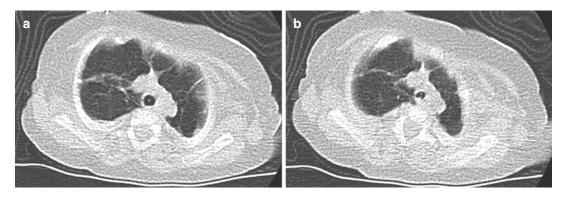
PEEP study. (a) Axial low-dose limited CT in a tracheostomy patient with BPD shows a patent trachea (*). (b) After lowering the PEEP settings, there is significant flattening of the trachea (*)
